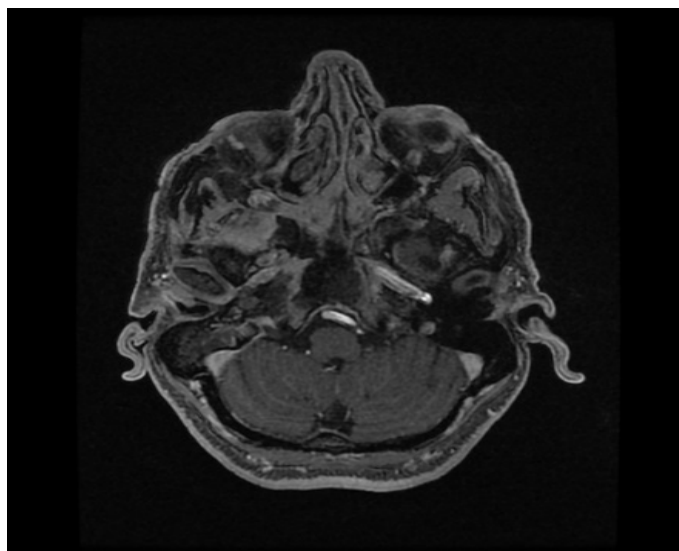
T1W MRI showing soft tissue enhancement in infra-temporal fossa and sphenoid wings.
